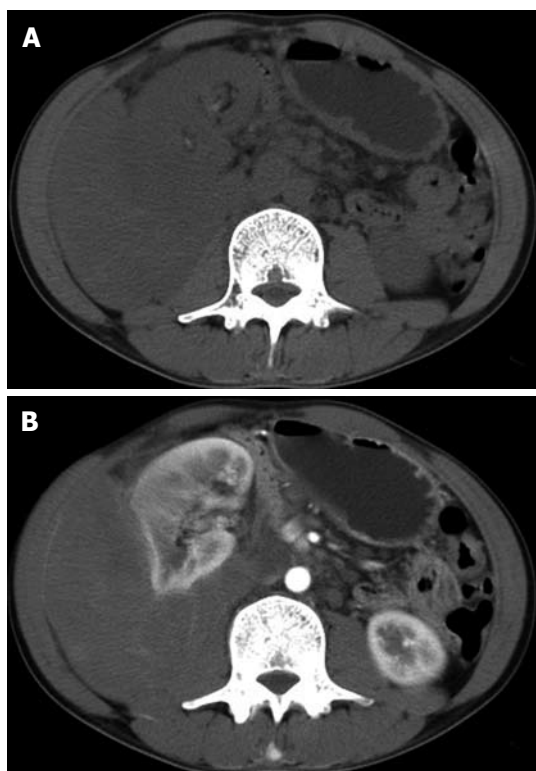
Abdominal computed tomography showing a large heterogeneous mass in the right retroperitoneal region, surrounding the posterior portion of the right kidney and compressing the right kidney (A), and slightly enhanced tumor tissue after injection of a contrast medium (B).
